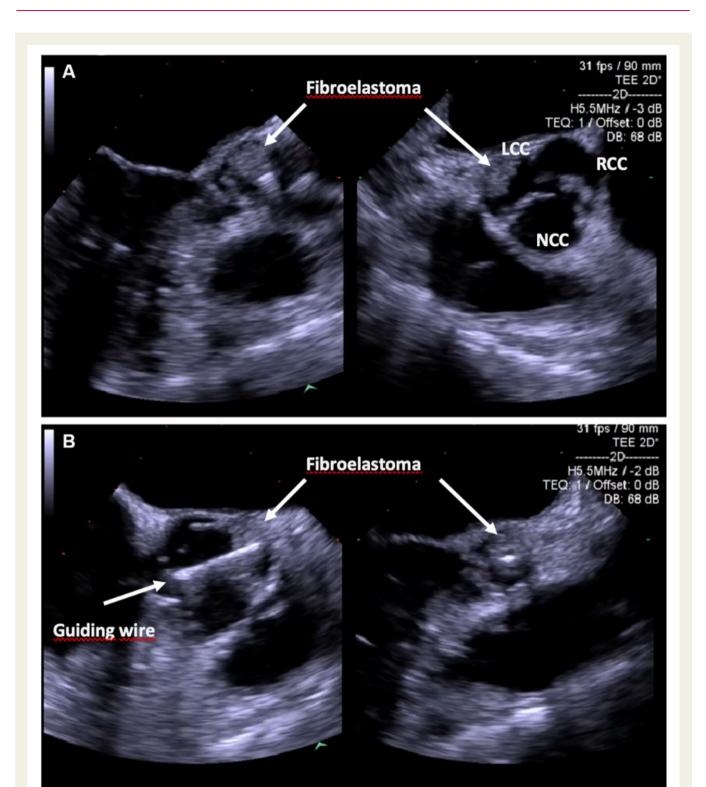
(A) Suspected tumour mass at the aortic valve and (B) transoesophageal echocardiography during left main coronary artery intervention with coronary guiding wire.
